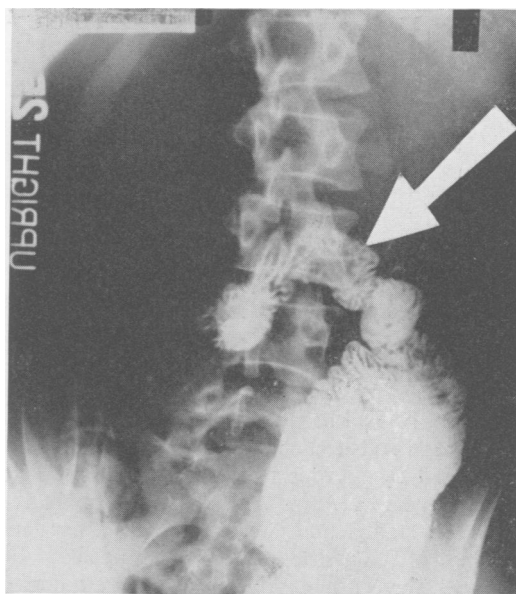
Upright gastro-intestinal x-ray four months postoperative 25 minutes after barium ingestion. Arrow points to level of duodenojejunal angle now at level of mid third lumbar vertebral body. See Figure 2.
